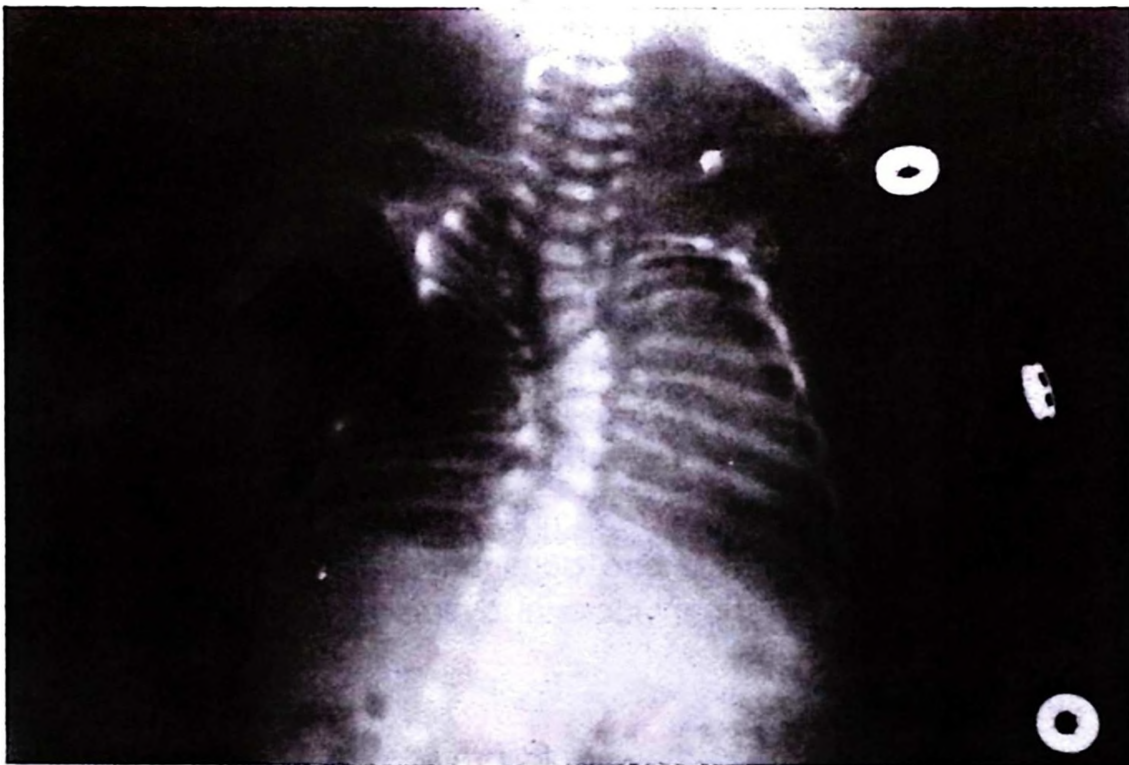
X-ray of the spine and thorax showing malformed vertebral bodies (hemivertebrae, vertebral fusions), scoliosis and marked costal anomalies with absent ribs.
